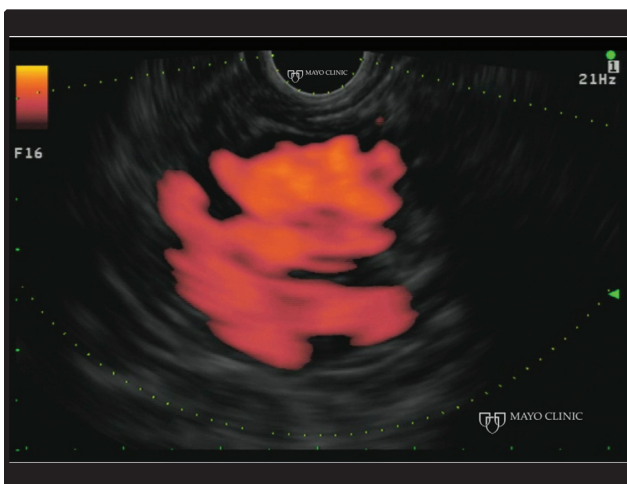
EUS power Doppler appearance of the gastric varices
